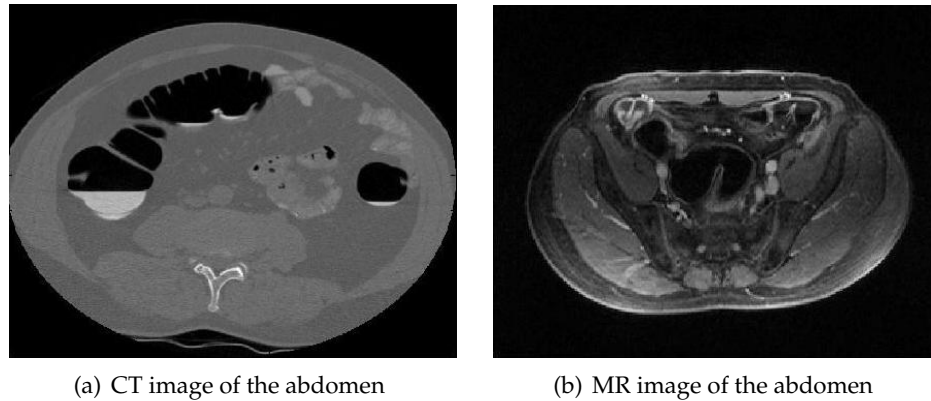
Comparison between CT and MR images
